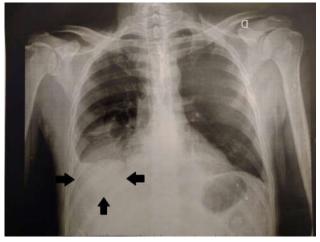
X-ray. Arrow: opacified region indicating pleural effusion in the right hemithorax.
